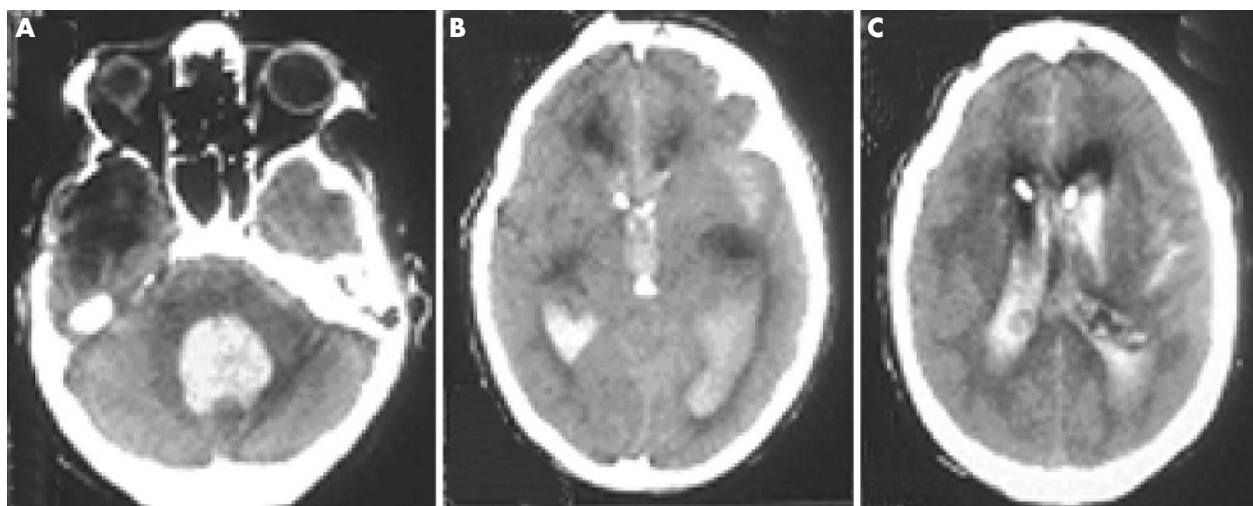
Preoperative computed tomography scan showing the massive intraventricular haemorrhage (IVH), with blood filling the fourth (A), third (B) and lateral (C) ventricles (patient 6).
